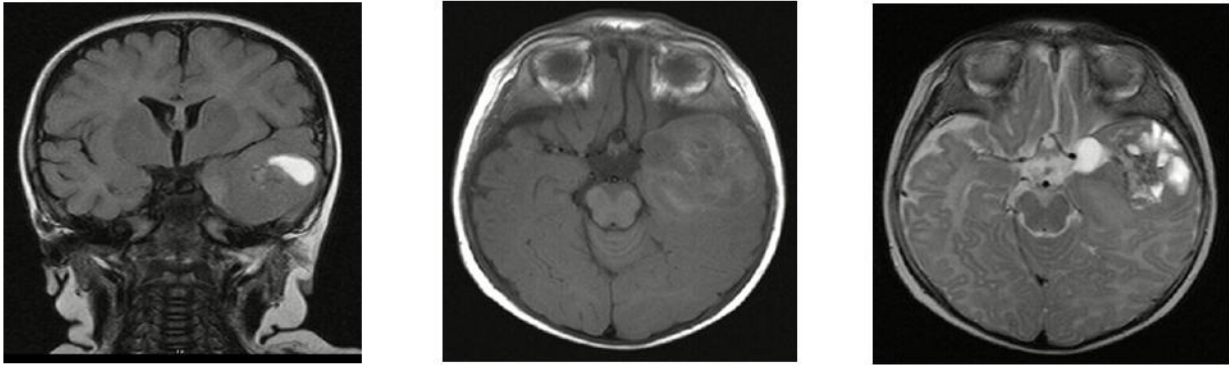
Preoperative T1-weighted MRI scans demonstrating a 40 mm × 45 mm × 40 mm left haemorrhagic temporal tumour with heterogeneous enhancement. (c) Heterogeneous intensity on T2-wieghted image showing haemorrhagic components
